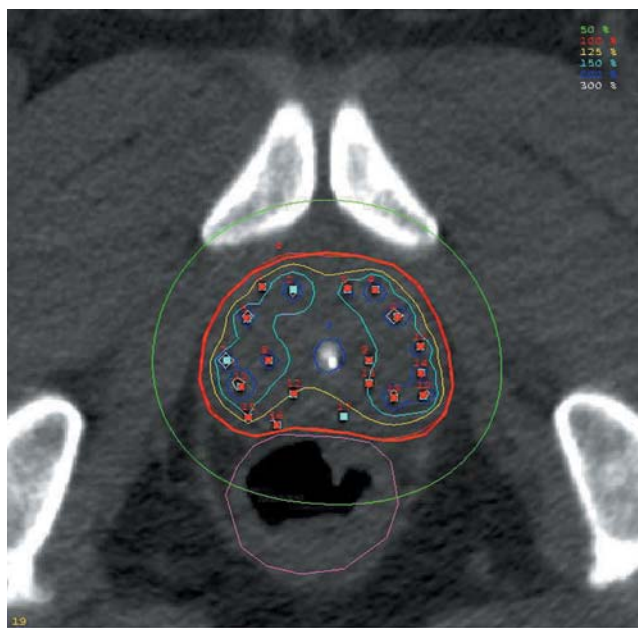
CT-based 3-D postplanning after implantation: evaluation of the isodose distribution in one representative CT slice within and surrounding the prostate and within the normal tissues (green: 50% isodose; red: 100% isodose; yellow: 125% isodose; light blue: 150% isodose; dark blue: 200% isodose).
